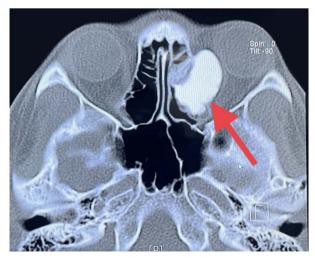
Axial view of CT paranasal sinus showing lesion extending from left ethmoid sinus into left orbital cavity (red arrow).
